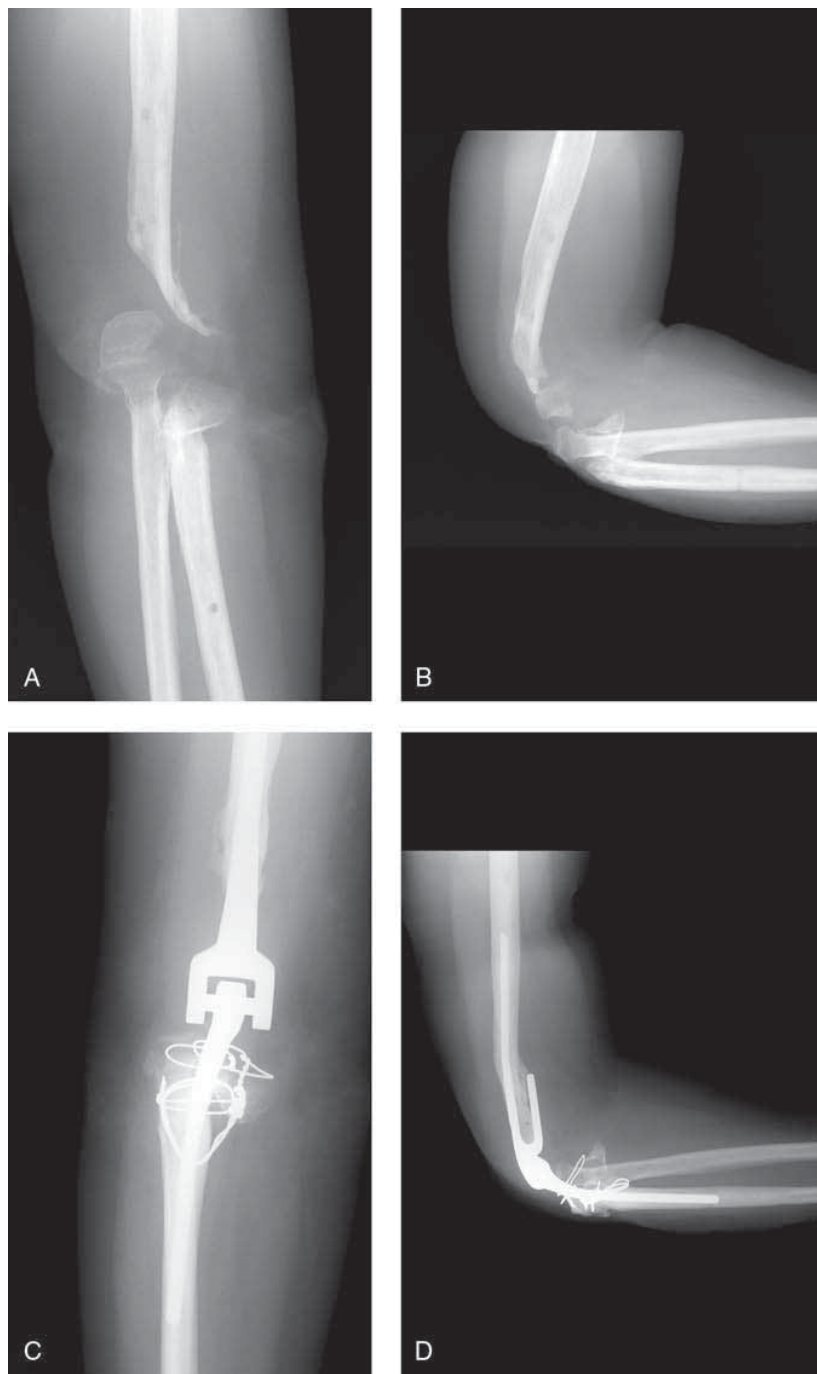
A and B, AP and lateral radiographs, respectively, showing a sideswipe fracture resulting in a flail extremity; there is no evidence of infection. The patient was in severe pain and did not want an allograft replacement. The patient lacked a triceps mechanism. C and D, AP and lateral radiographs, respectively, taken 1 year after reconstruction using a semiconstrained implant with an allograft Achilles tendon and a calcaneal graft to the proximal ulna. The patient was able to extend the elbow against gravity.
